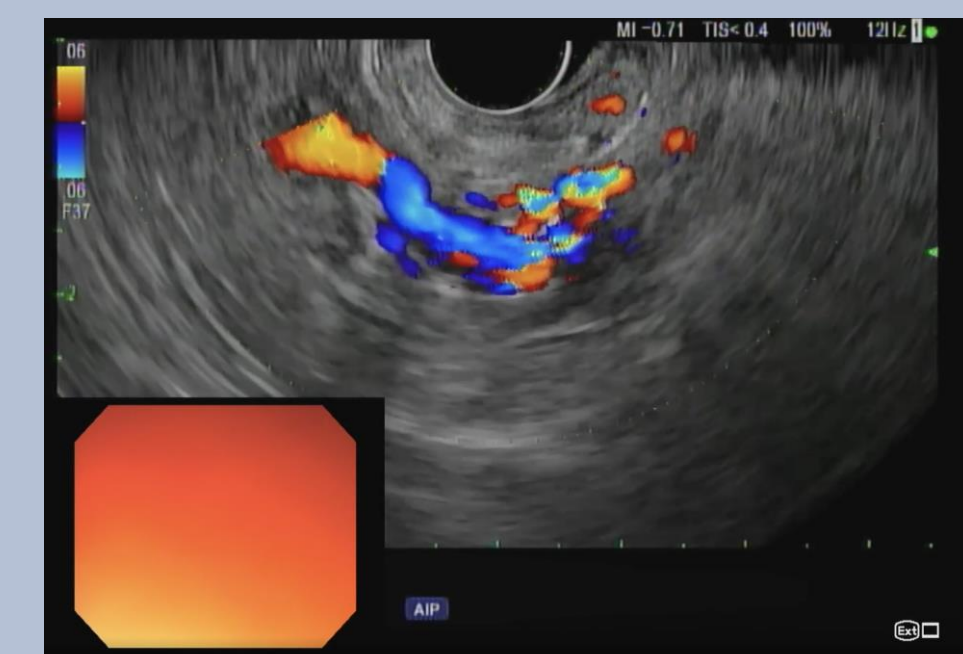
Multiple tubal anechoic structures consistent with varices were noted with flow seen on doppler examination.
